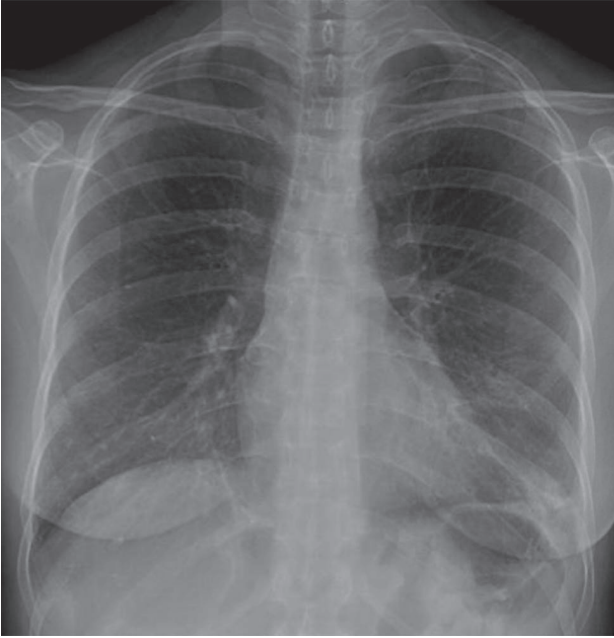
Chest radiograph at 6 weeks after hospital discharge showed markedly improved consolidation and a residual left-sided pleural effusion.
